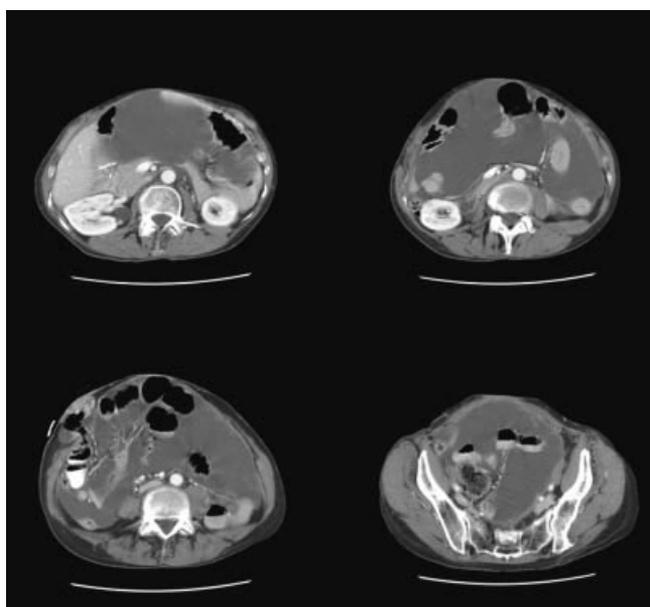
Representative CT Scan images (January 30, 2006) <2 years after third operative intervention without HIPEC demonstrating recurrence of extensive mucinous peritoneal carcinomatosis.
